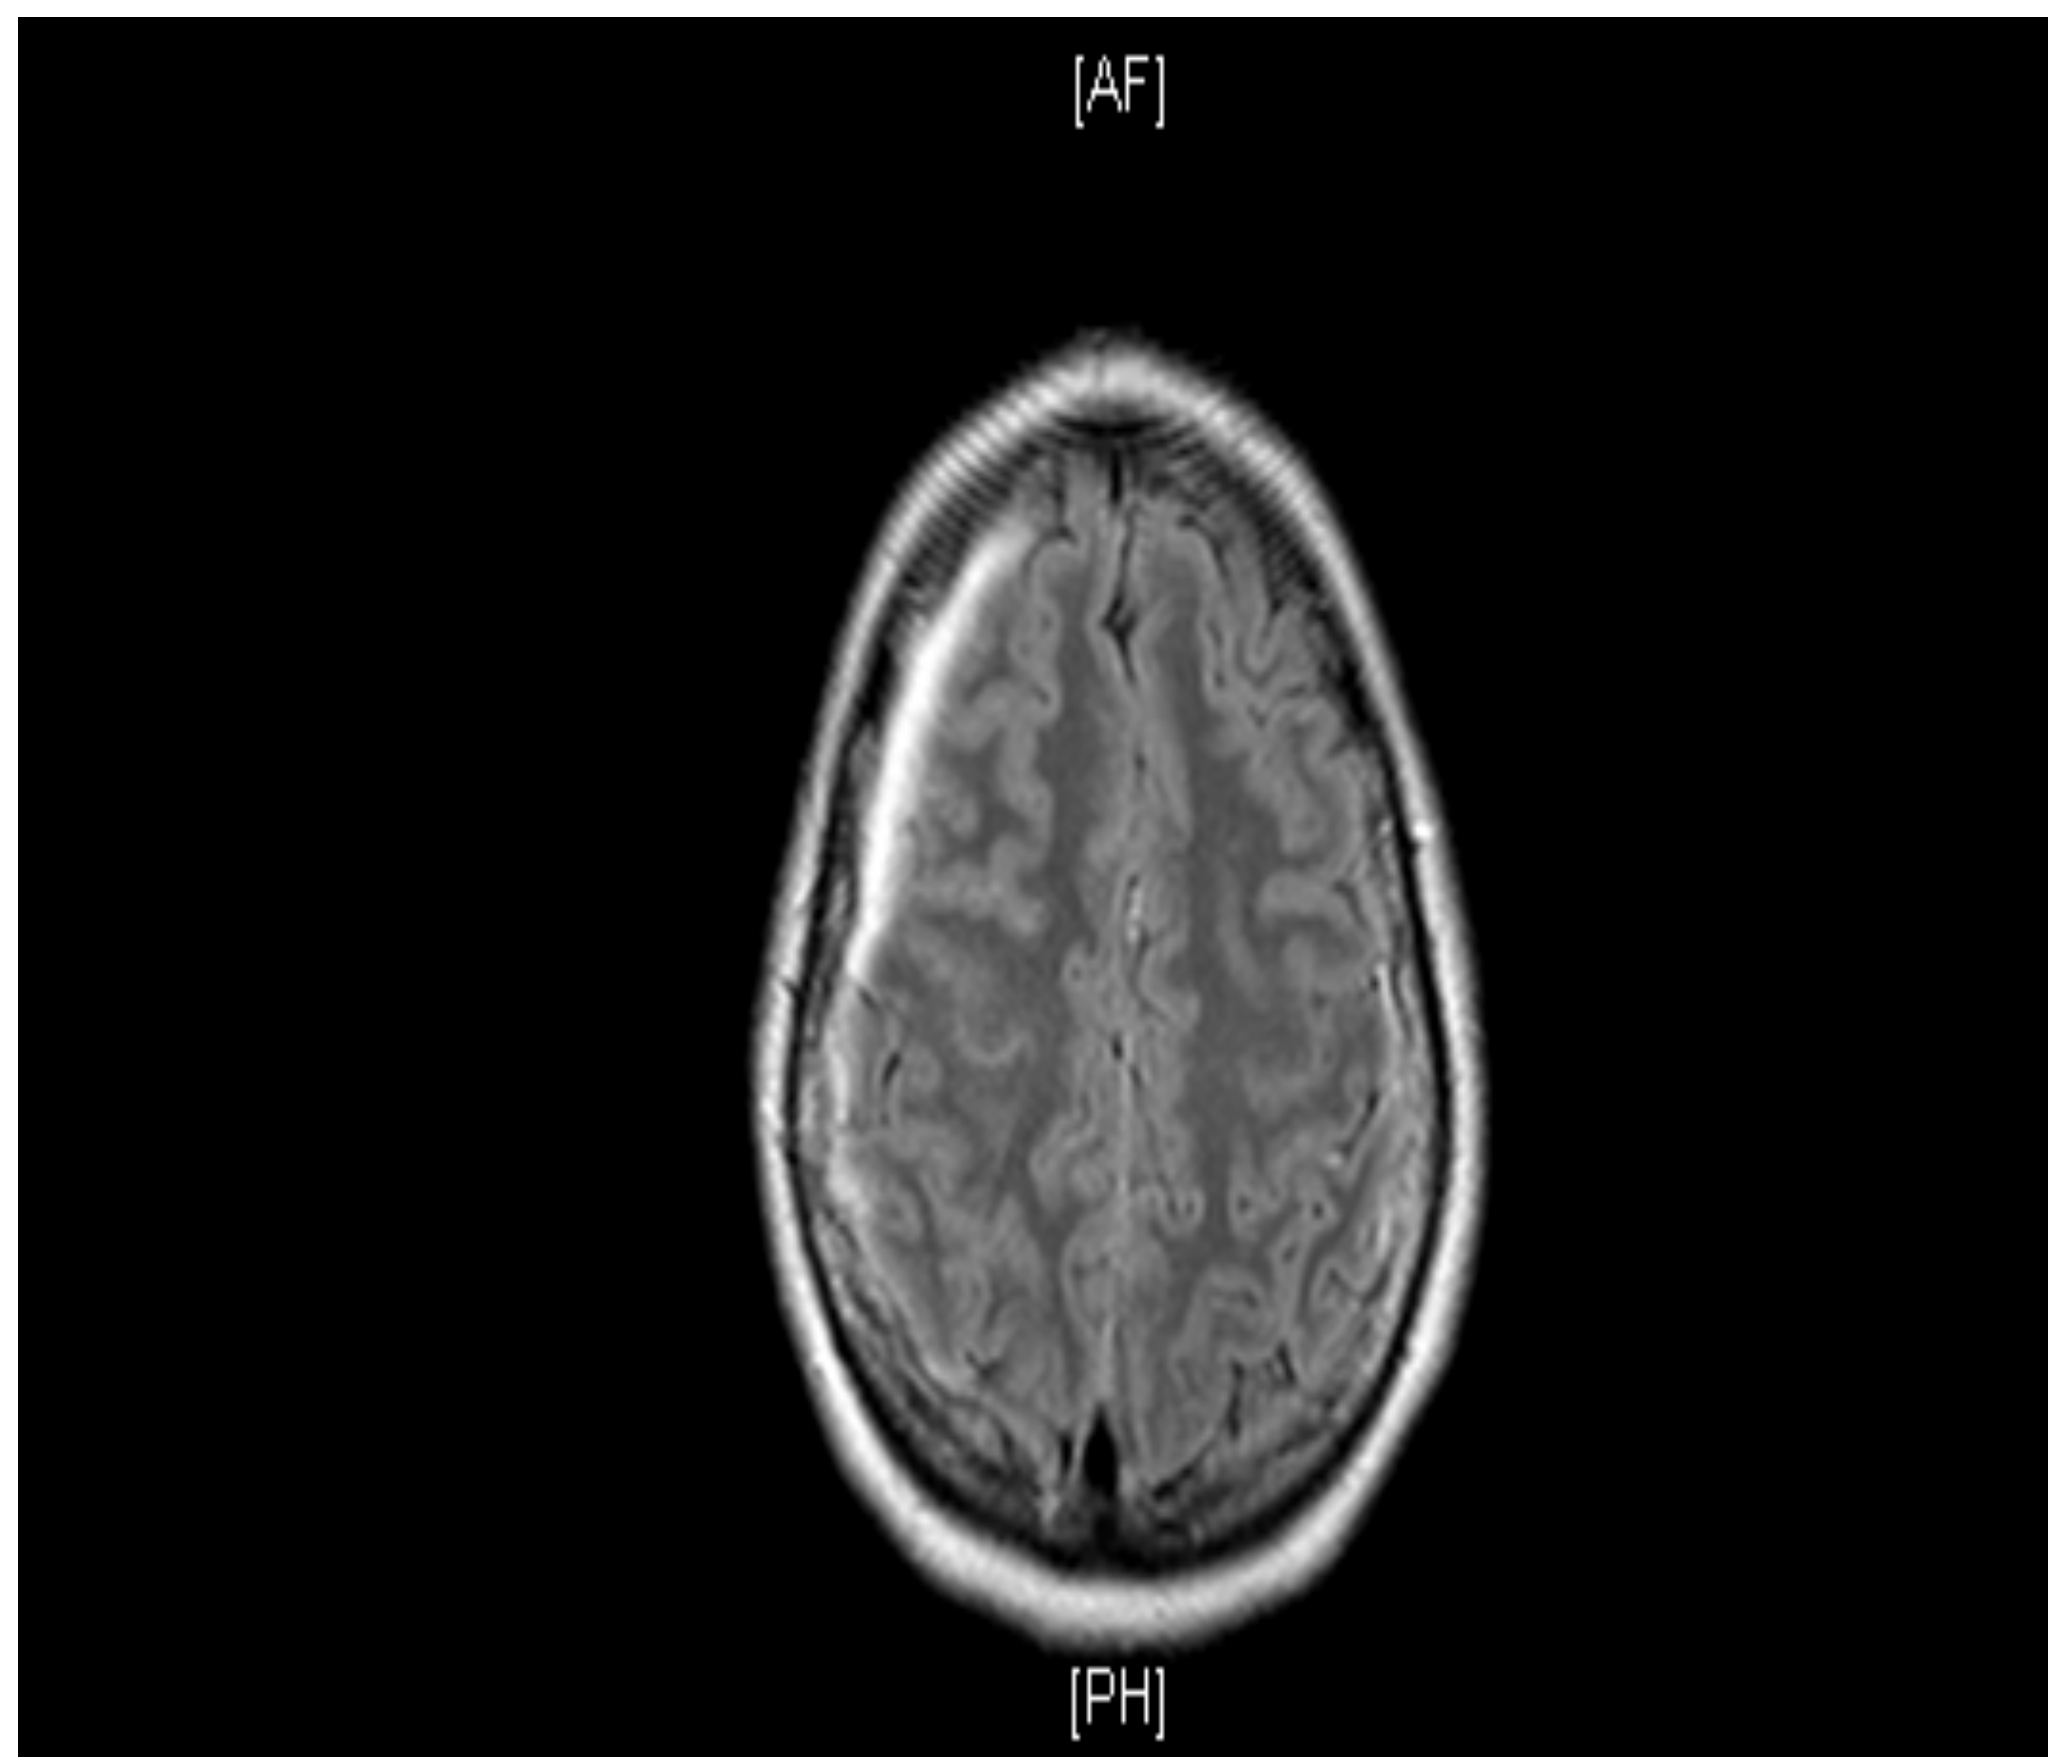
CT scan: Axial View of Head. A 6mm subdural hematoma is displayed in the right hemisphere.
